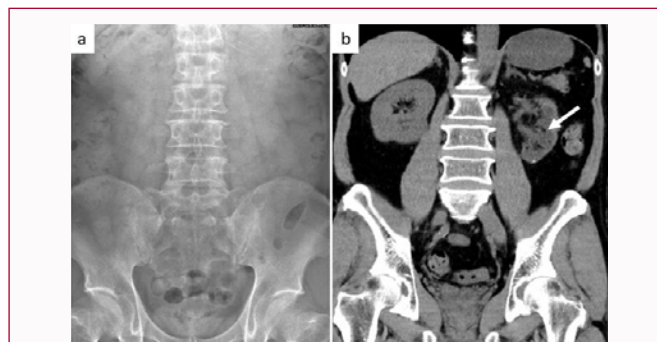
Postoperative image of KUB and CT. a) KUB shows stone free status. b) Arrow indicates to disappear hydronephrosis and remove all stone fragments in left kidney.
